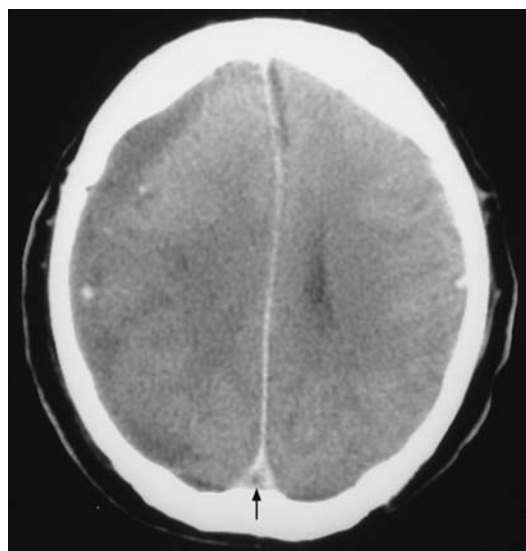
CT scan post i.v. contrast. Low-density subdural collection with mass effect. Note fluid in the interhemispheric fissure, which suggests a subdural empyema. This is complicated by a sagittal sinus thrombosis (arrow points to the delta sign).
